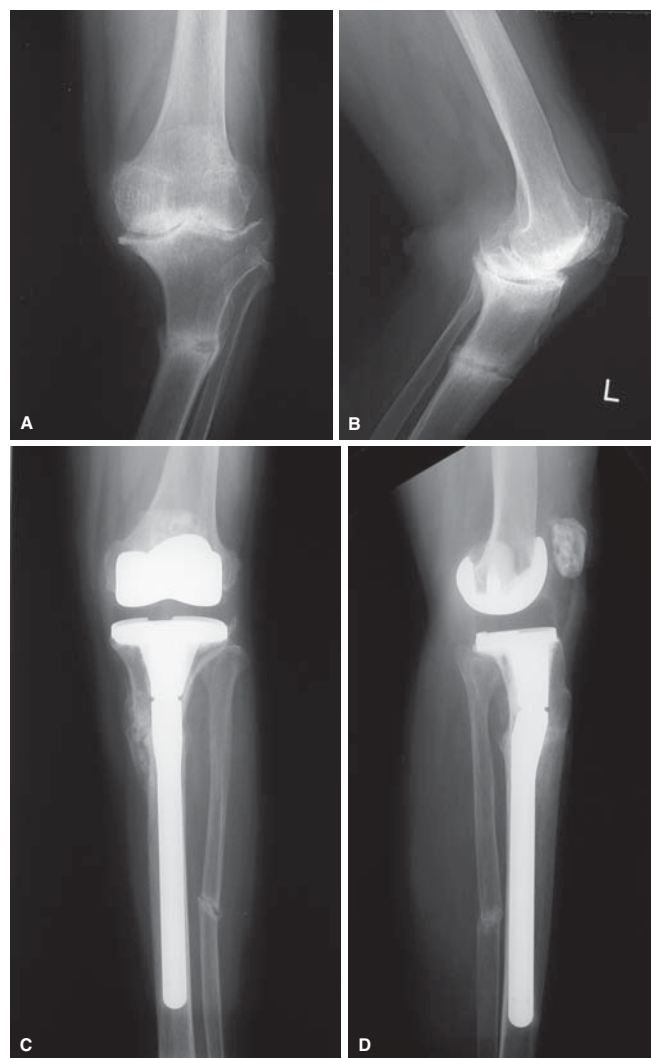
Case 4. Anteroposterior and lateral radiographs (A and B, respectively) showed a stress fracture of the uppermost third of the left tibia. Five months postoperatively, anteroposterior and lateral radiographs (C and D) showed union and good alignment of components
